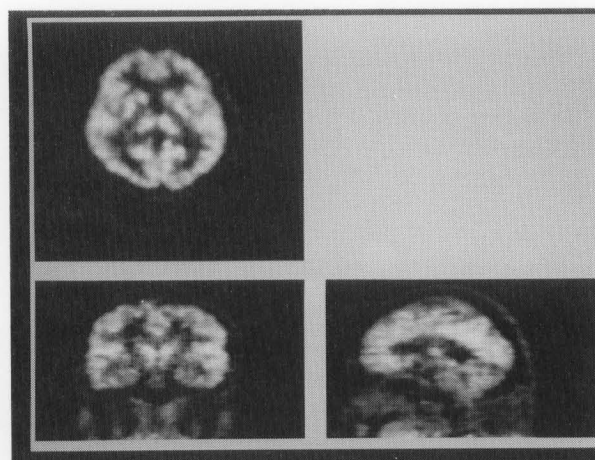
Brain images of the accumulation of ^{18}F -FDG in a normal volunteer. A total of 6.4×10^6 counts per center slice was obtained. All 63 images were resliced to coronal, and sagittal images. The advantage of a large axial FOV is that patient positioning is not as critical in terms of imaging the entire brain.
